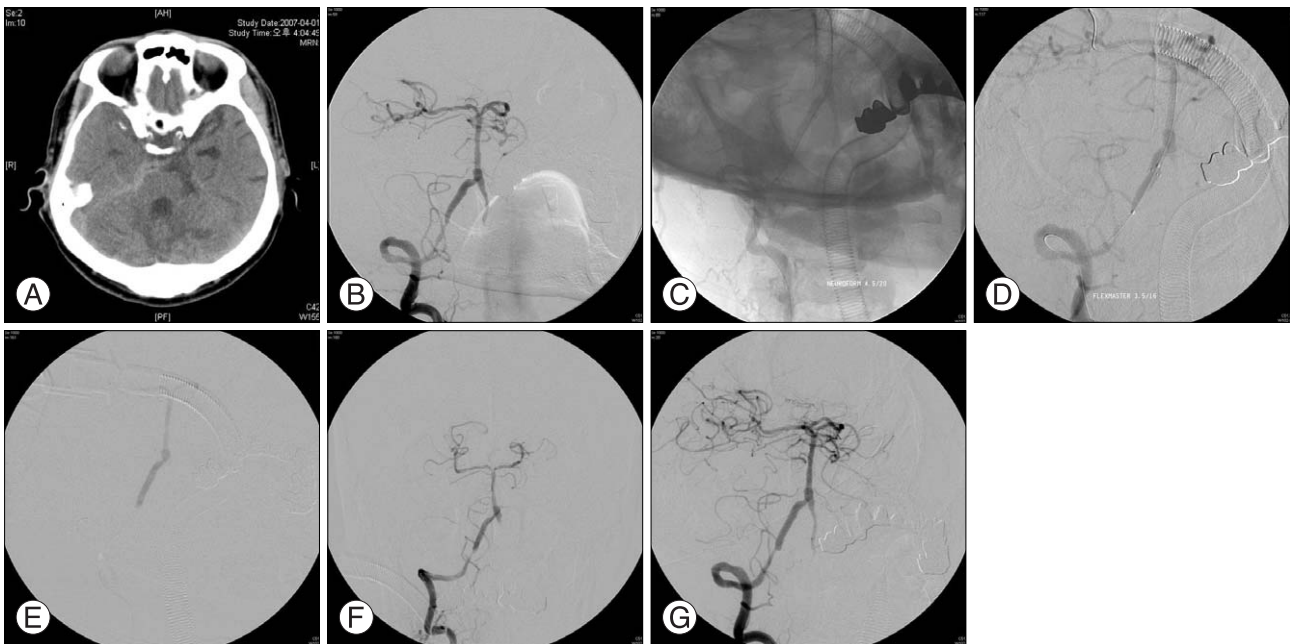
CT scan and angiograms in a 71-year-old man with a dissecting aneurysm of the distal intracranial right vertebral artery treated by double stents method. (A) Initial CT scan demonstrating SAH. (B) Anteroposterior projection shows a fusiform dilatation of the right distal vertebral artery and vertebrobasilar junction with severe stenosis on the free posterior inferior cerebellar artery segment. (C) The first stent (Neuroform 4.5 × 20) is deployed across the vertebrobasilar junction. (D) The second stent (Flexmaster 3.5 × 16) is placed on the proximal side of the first stent in an overlapping manner. (E) Acute thrombosis is developed at the second stent deploying site. (F) Angiogram obtained immediately after the intraarterial infusion of urokinase 100,000 U and Tirofiban 2.5 mg demonstrates complete recanalization of the right vertebral artery. (G) Angiogram obtained 8 days after stent placement reveals stable incomplete healing of the aneurysm.
